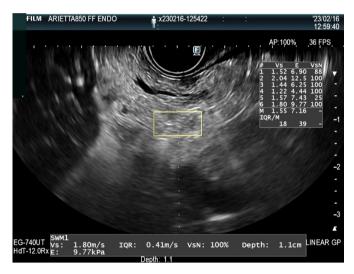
Endoscopic ultrasound-guided shear wave elastographic evaluation of a patient with early changes of chronic pancreatitis. In the top of the screen the box is showing the mean velocity (Vs) (1.55) and Kpascales (Kpas) (7.16).
